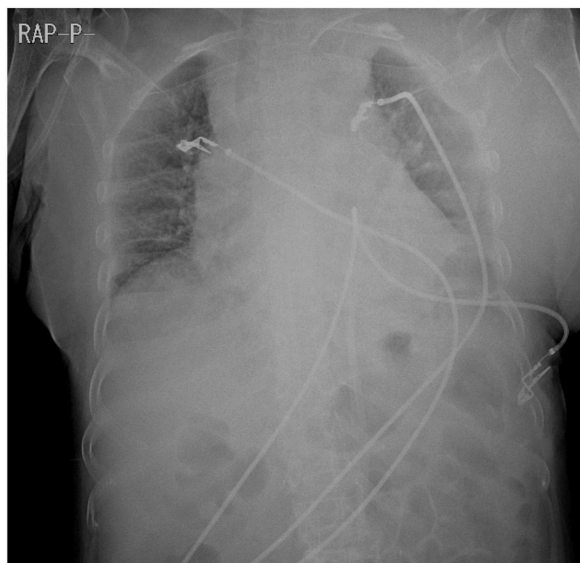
Chest X-ray on POD7 (event day morning).
